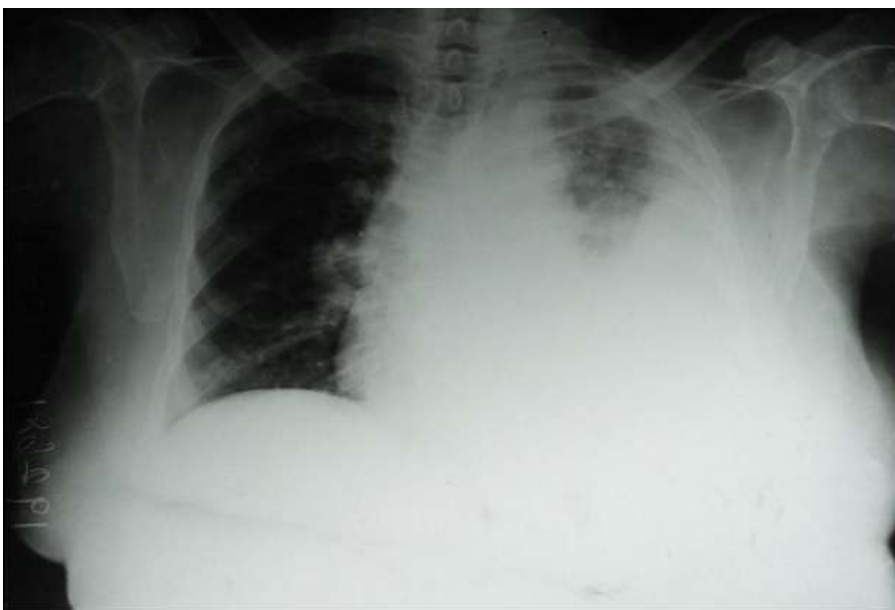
chest X-ray showing pleural effusion without significant mediastinal shift
